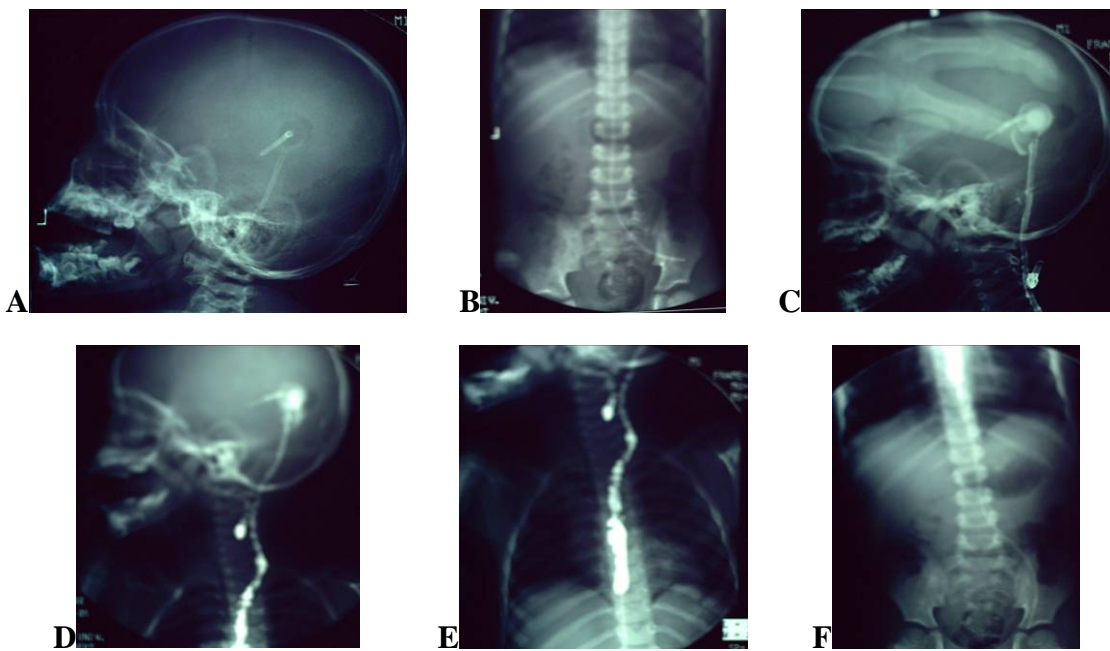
Case 16: female patient, 5ys old, radiographic shuntogram revealed no free peritoneal spilling of contrast material even after post pumping test denoting distal obstruction.
